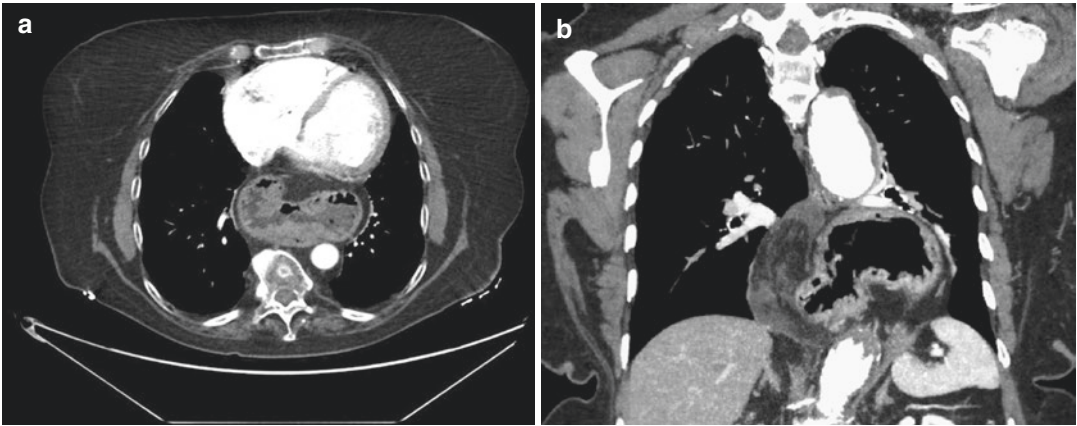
(a, b) Axial and coronal CT scan images revealing paraesophageal hernia with the stomach in the retrocardiac mediastinal cavity
